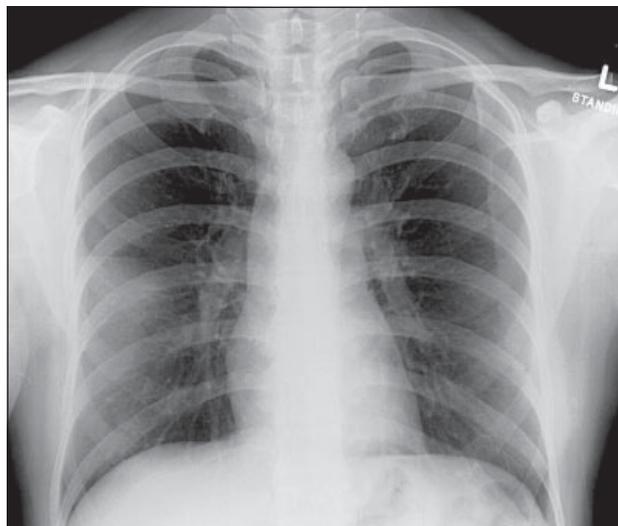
Frontal chest X-ray of a 44-year-old woman with severe acute respiratory syndrome, showing ill-defined air space opacification in the periphery of the middle lobe superiorly abutting the horizontal fissure. There is no cavitation, hilar lymphadenopathy, or pleural effusion.
